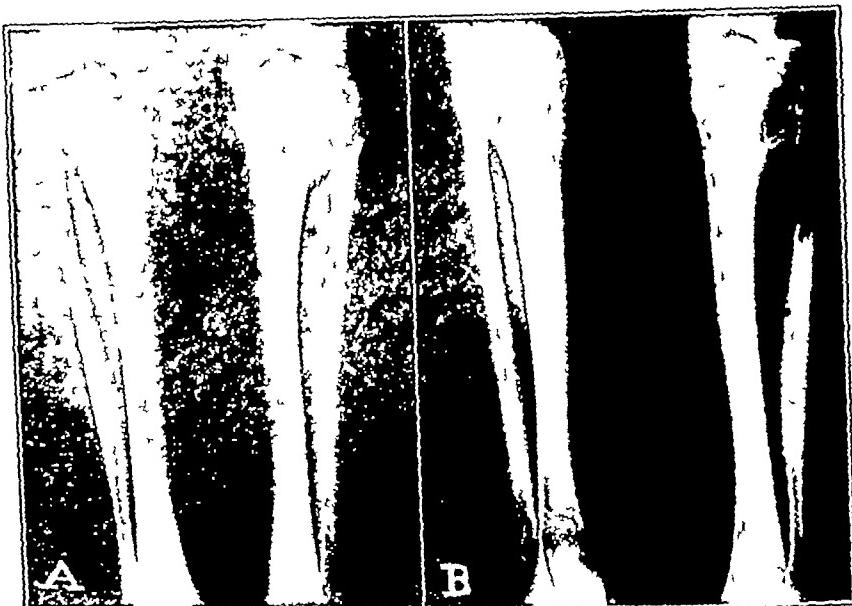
Roentgenograms showing benign giant cell tumor at proximal extremity of left tibia. In A, the lesion is shown preoperatively. The corresponding view of the right tibia is normal. In B, the lesion twenty-two months postoperatively shows an increase in extent despite surgical and radiation therapy.
